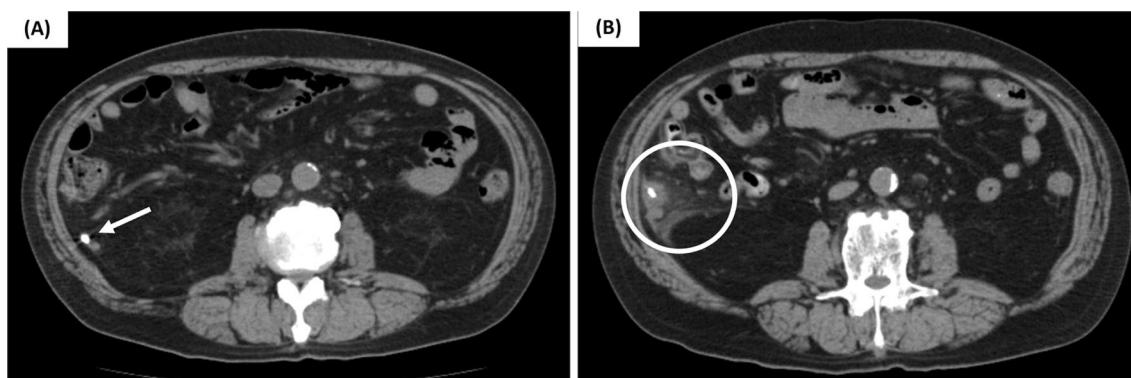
a Abdominal CT performed 2 years ago. An endoscopic clip was found in the appendix (white arrow). b Abdominal CT on admission revealed appendicitis gangrenosa and the presence of an endoscopic clip in the appendix (white circle). *CT* computed tomography
